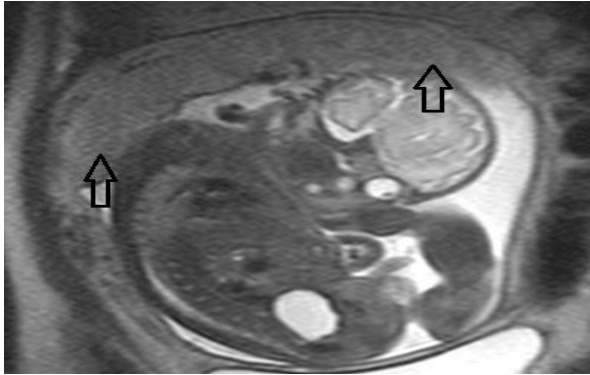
Coronal T2W MRI image of normal 29 weeks fetus with homogenous disc shaped (arrows) placenta
